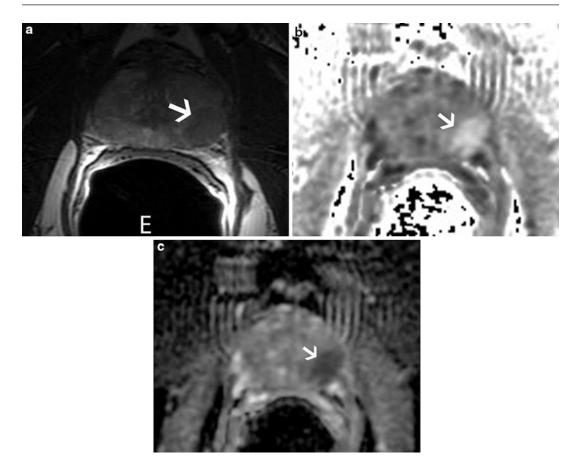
A 57-year-old man with prostate cancer. Axial, T2-weighted MRI (a) obtained with endorectal coil shows a low-signal intensity area (*arrow*), which may represent patient's known cancer. The abnormal
